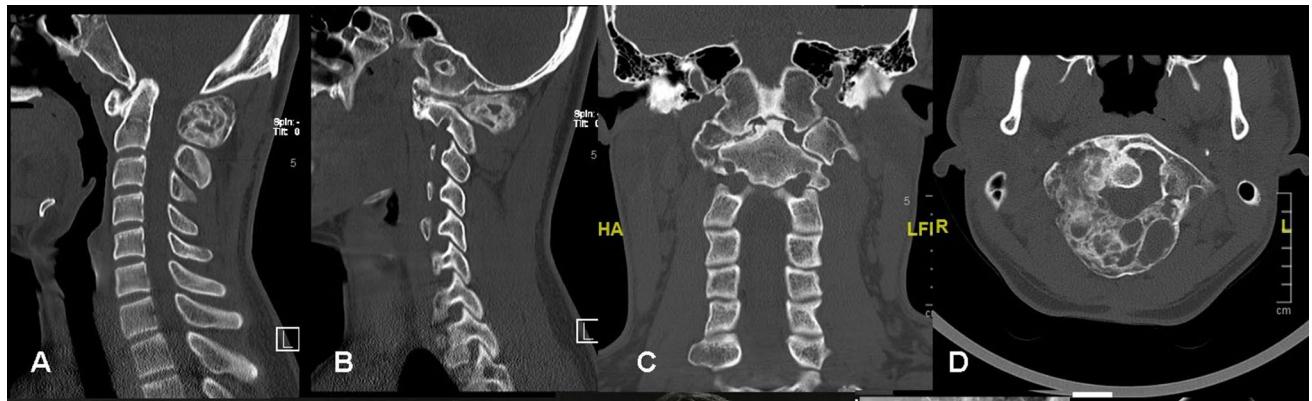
CT-Scan at 12 months of follow-up after completion of 12-months therapy with denosumab; a sagittal view, b right parasagittal view, c coronal view, d axial view
